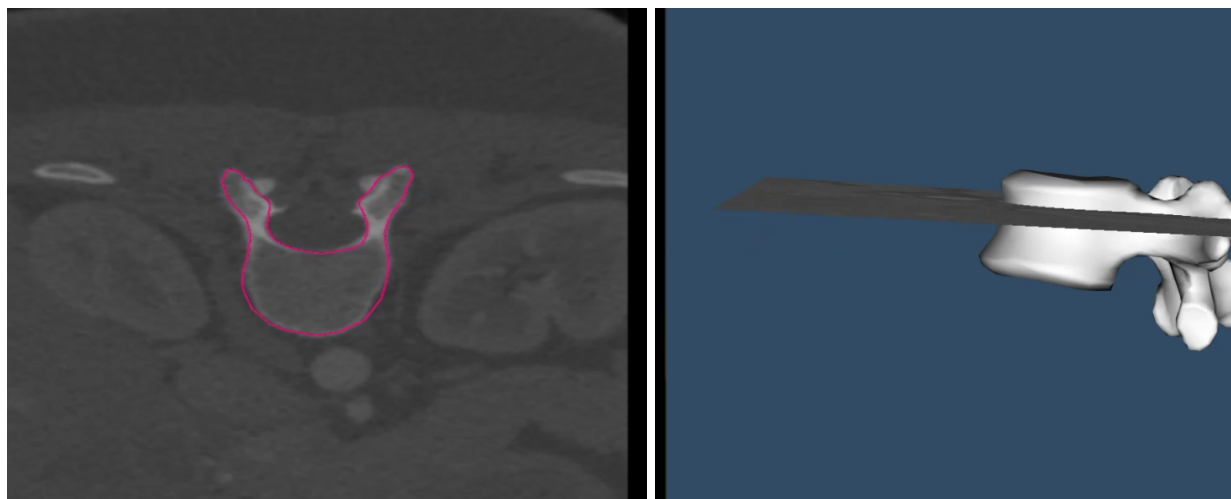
Screenshots of the warped CAD of the L1 vertebra overlaid on a transverse L1 vertebra CT image.
